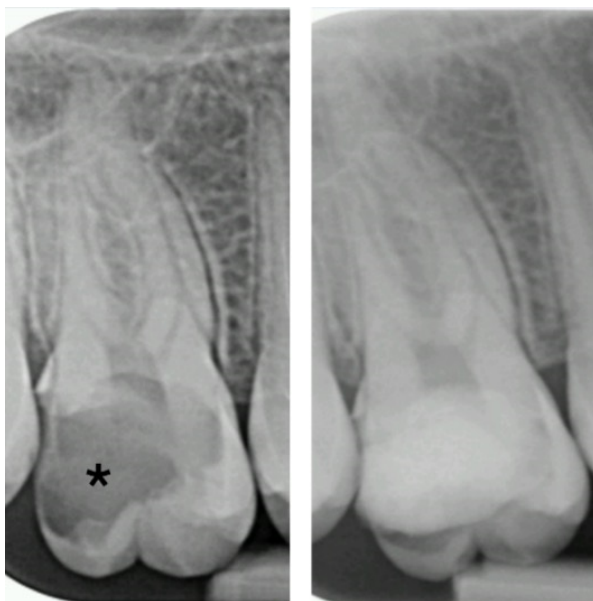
Intraoral X-ray of tooth #16 before and after carie (*) treatment.
